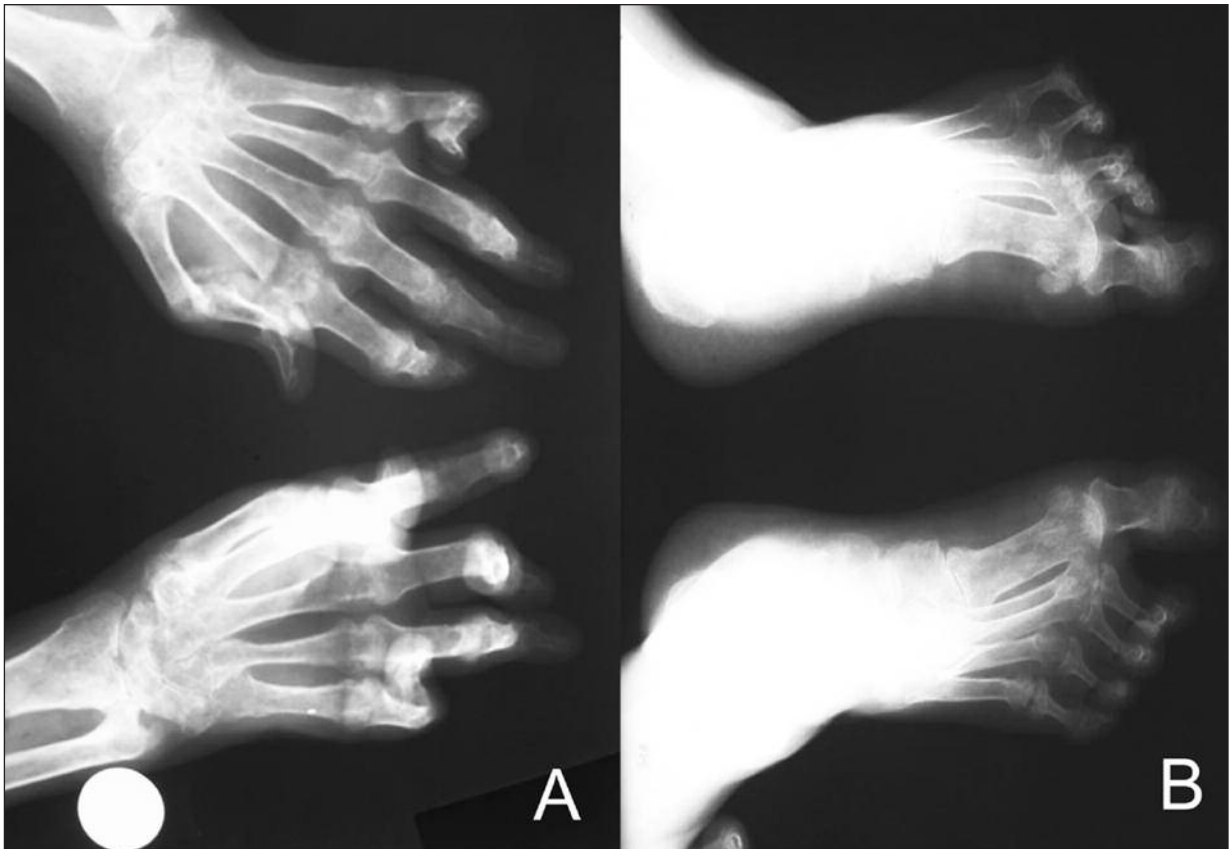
(A-B) Radiographic images of the patients hands and feet showing rheumatoid arthritis deformities
